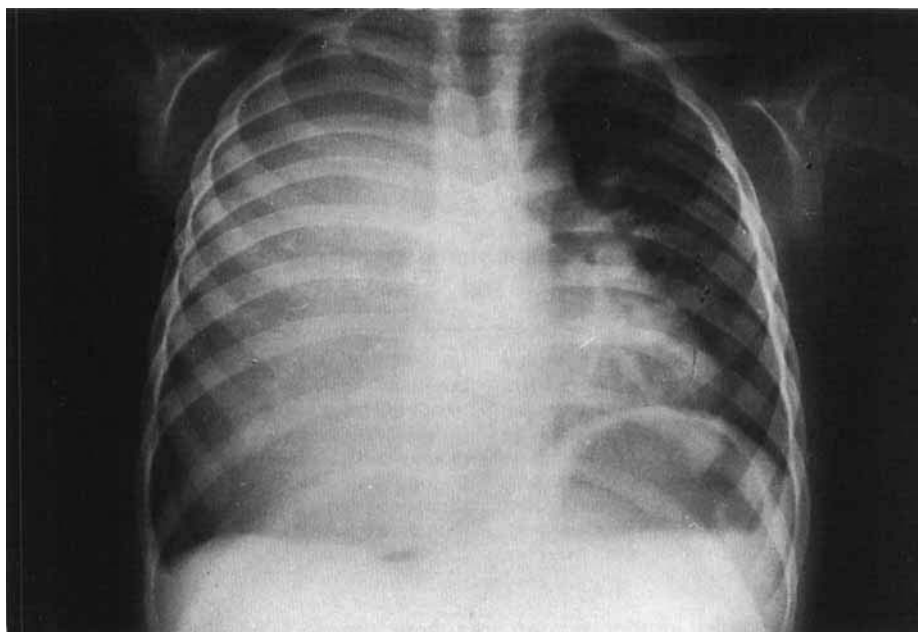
In case 1, a chest X-ray shows a density in the right hemithorax with inferior displacement of the right main bronchus and dislocation of the heart and mediastinum to the left.
